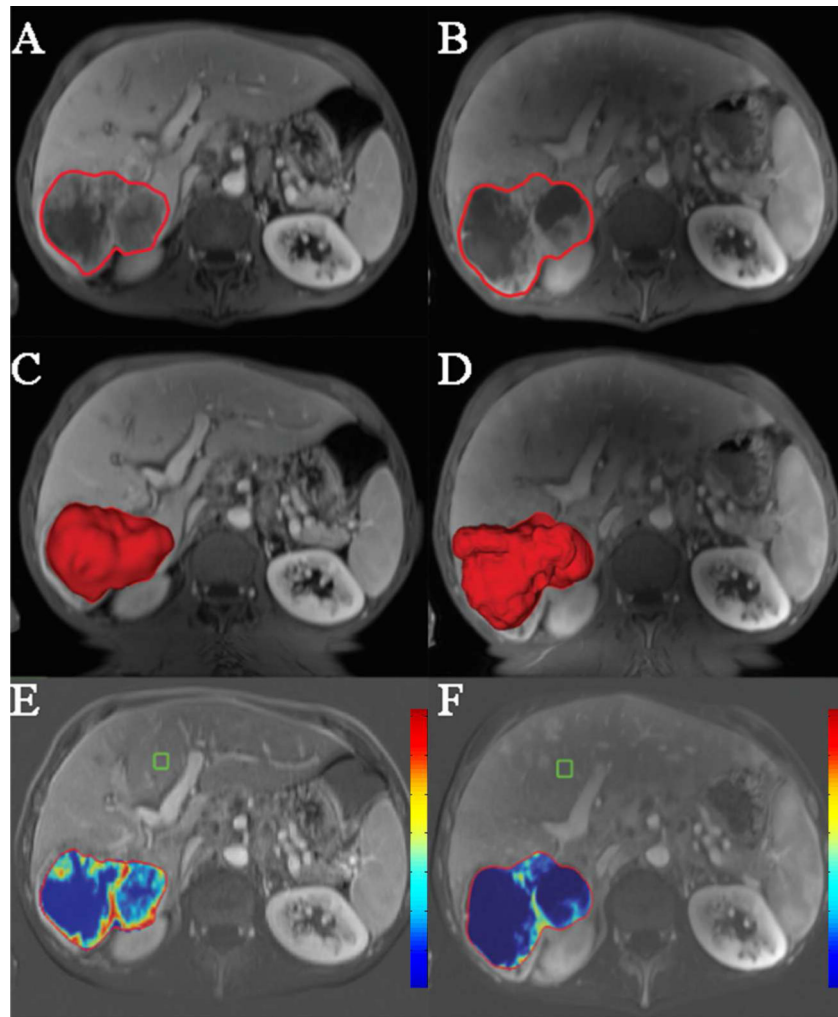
3D quantitative assessment technique. The *left column* represents baseline imaging, while the *right column* represents the follow-up MRI post TACE. a, b Semiautomated tumour segmentation on a representative, contrast-enhanced T1-weighted MR sequence. Of note, a and b are images prior to the subtraction. c, d Volume rendering for the segmented tumour in a 3D model of the upper abdomen. e, f qEASL colour maps of the tumour after subtraction (*red* maximum enhancement, *blue* no enhancement, normalized by the ROI). The selected patient had stable disease according to RECIST, WHO, vRECIST and partial response according to EASL, mRECIST and qEASL
